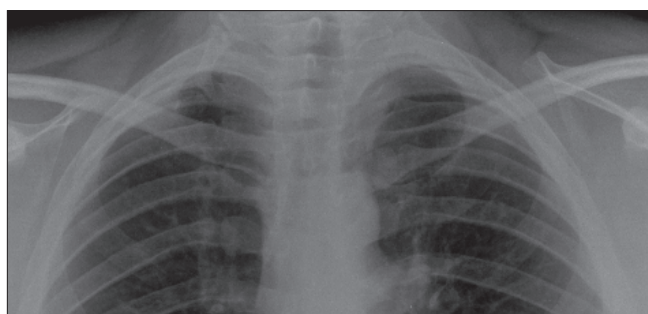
Results of chest x-ray of right cervical rib.
